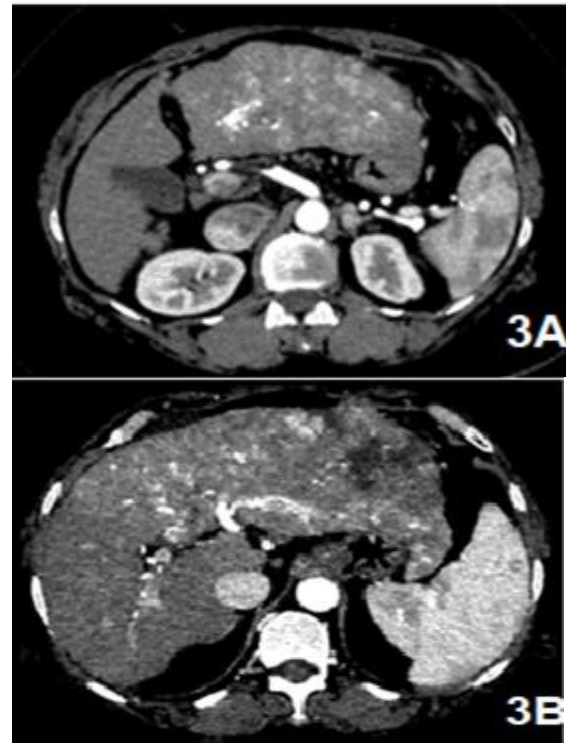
shows disease progression of HCC in 58 years old female. 3A: Pre-Sorafenib CT scan shows an arterialized infiltrating HCC in the left lobe left lateral segments with the involvement of left lateral branch of the portal vein. 3B: post sorafenib axial slice on the follow up triphasic CT scan at same level in arterial phase shows interval disease progression of HCC involving segment IV along with left lateral segments and in left portal vein.
